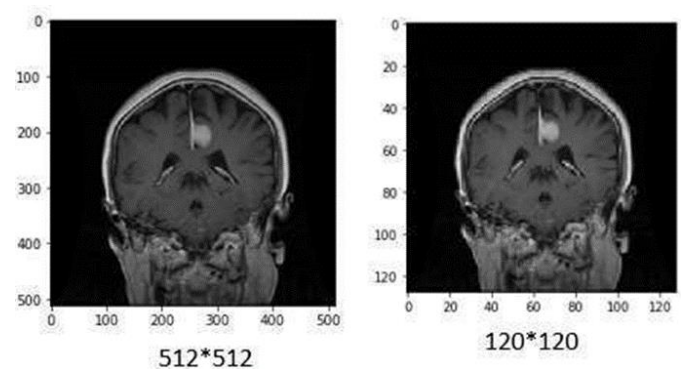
Resizing of CT images.
